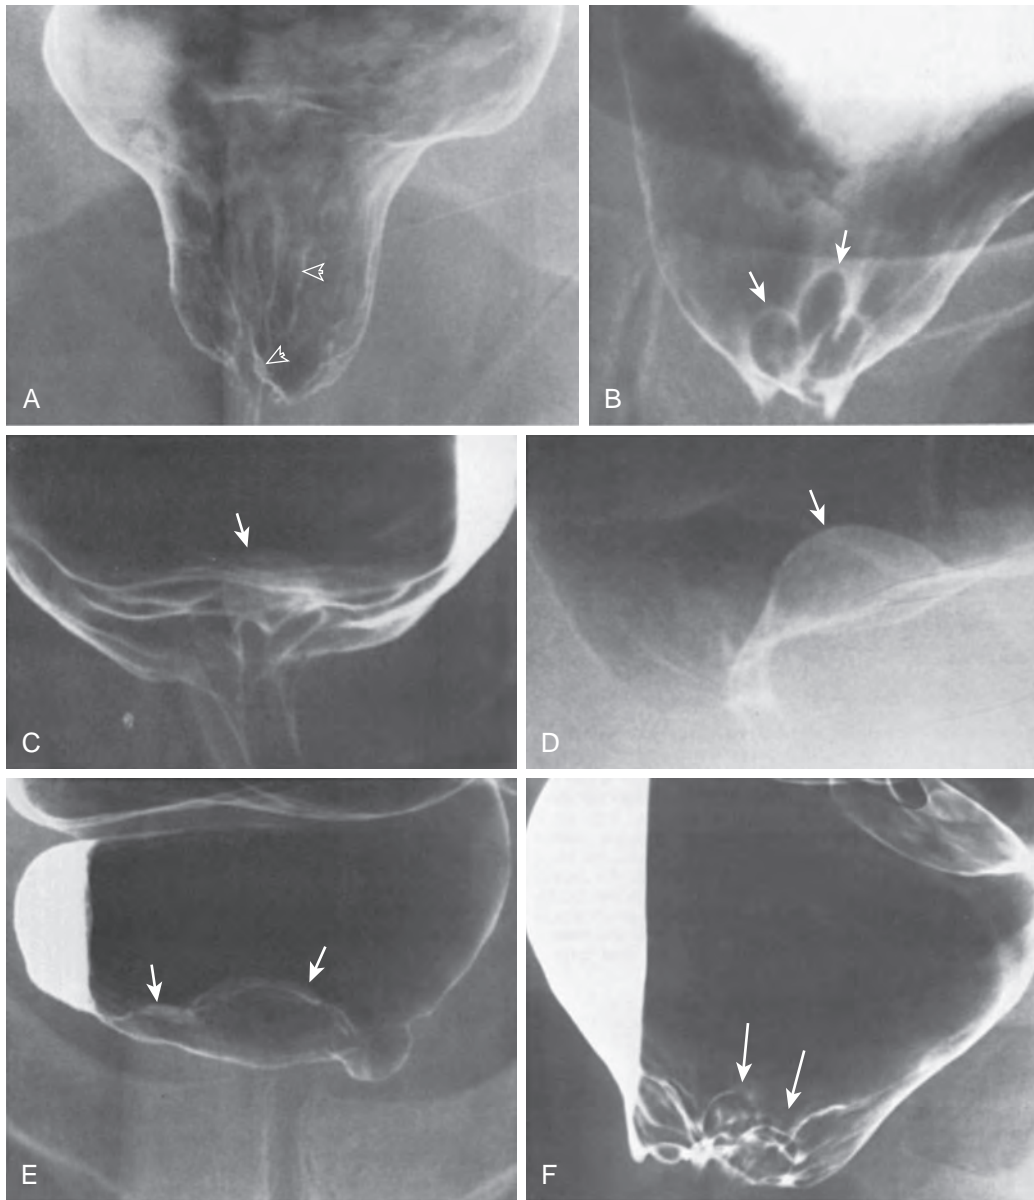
Radiographic appearance of internal hemorrhoids. A. Lobulated folds. Mild lobulation of anorectal folds (arrowheads) that extends less than 3 cm above the anorectal junction is a typical radiographic finding for internal hemorrhoids. B. "Bunch of grapes." Three smooth-surfaced polyps (arrows) are clustered above the anorectal junction. This radiographic appearance is typical of internal hemorrhoids. C. Solitary polyp. A smooth-surfaced polyp (arrow) projects from mildly lobulated columns of Morgagni. This is a nonspecific radiographic appearance that requires endoscopy. D. Submucosal mass. A smooth-surfaced mass (arrow) with relatively abrupt angulation to the colonic contour is typical of a submucosal mass. Although this is a typical radiographic appearance of internal hemorrhoids, other submucosal rectal masses include lymphoid polyps and solitary rectal ulcers. E. Masslike internal hemorrhoid. A large mass (arrows) in the distal rectum has a focally irregular surface pattern. This huge internal hemorrhoid cannot be distinguished from other rectal masses, such as carcinoma or cloacogenic carcinoma. Endoscopy and biopsy are necessary. F. Multiple polypoid folds. Large polypoid folds (arrows) with a nodular surface pattern in the distal rectum. Although these radiographic findings are typically seen with internal hemorrhoids, they may also be caused by solitary rectal ulcer syndrome, various forms of proctitis, or an unusual infiltrating tumor.
